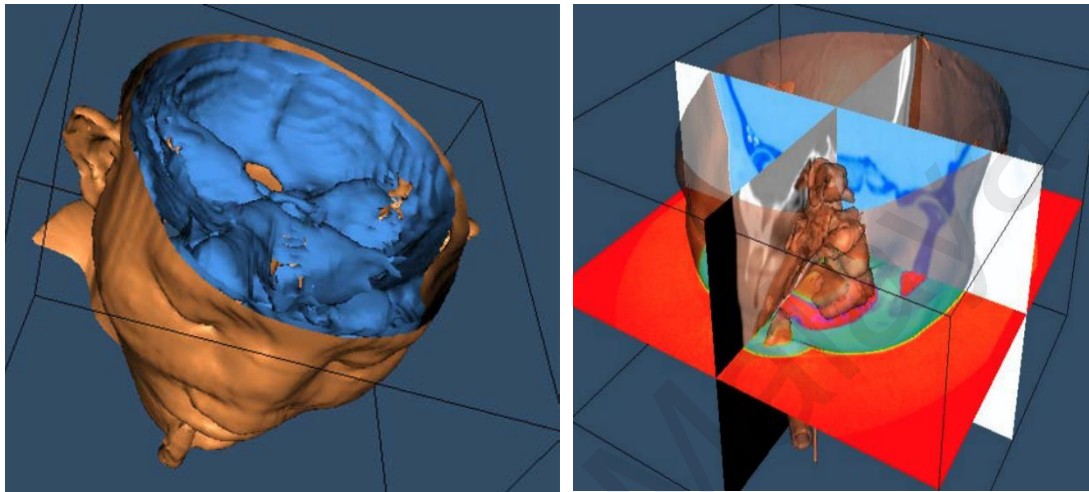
2 Volumetric Rendering Results of CT Head Image. (89 2D images)
